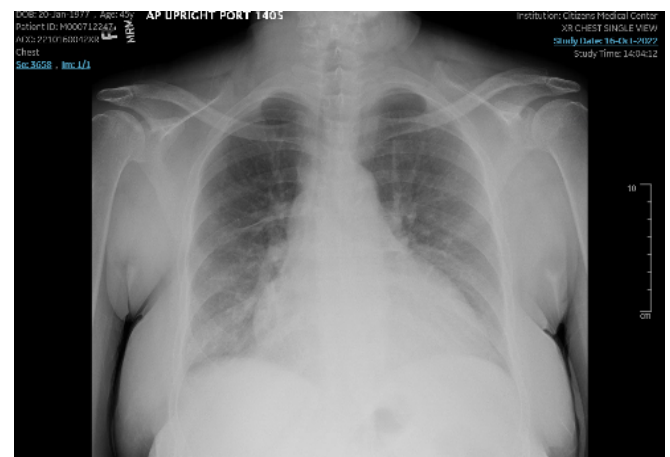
Cardiomegaly with mild bibasilar pulmonary opacities on Chest X-Ray.
